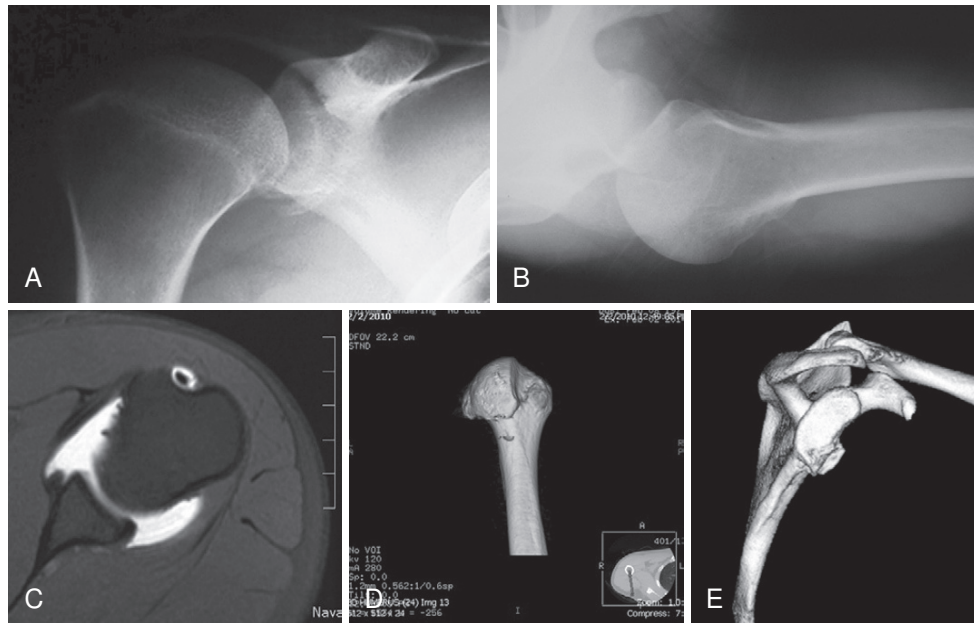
Various imaging studies to demonstrate examples of glenohumeral instability. Anteroposterior (A) and axillary (B) radiographs that demonstrate an anterior bony Bankart injury sustained after an anterior shoulder dislocation. A magnetic resonance arthrogram that demonstrates an anterior labral tear (C). A computed tomography (CT) scan with three-dimensional reconstruction demonstrating a large Hill-Sachs injury (D). A CT scan sagittal oblique image that shows glenoid bone loss (approximately 25%) and bony Bankart injury with some attrition of the injured bone (E).
